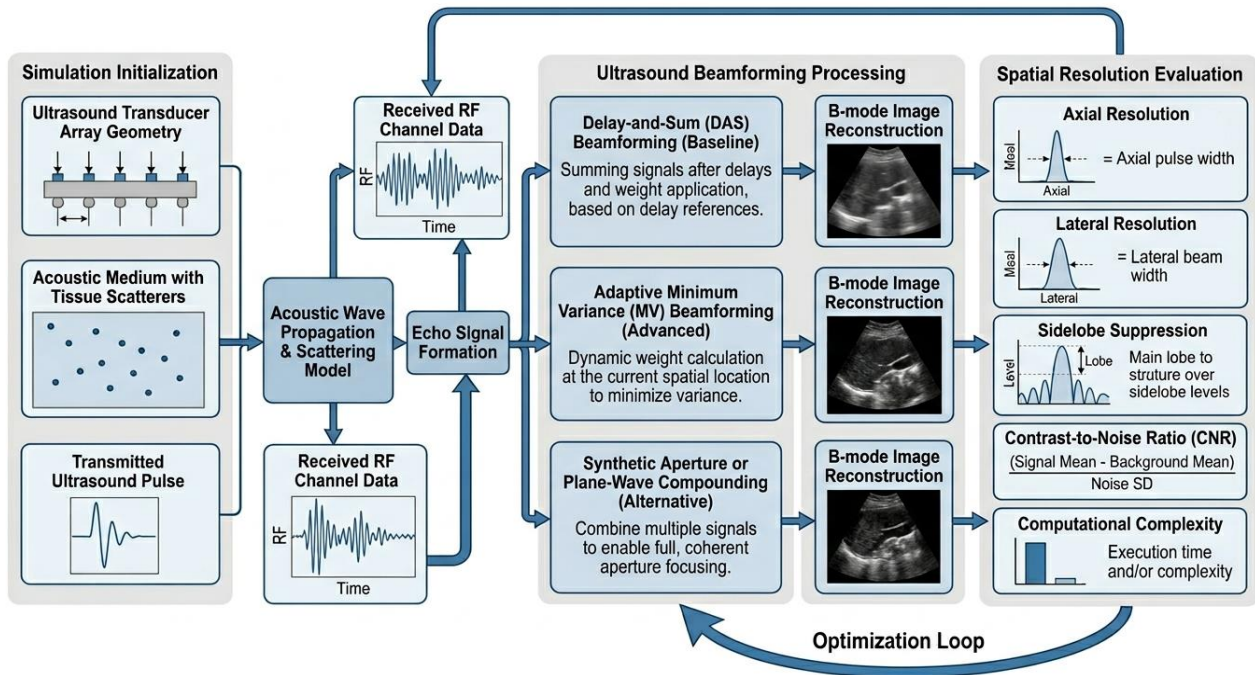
Numerical modeling framework for optimizing ultrasound beamforming algorithms and improving spatial resolution
